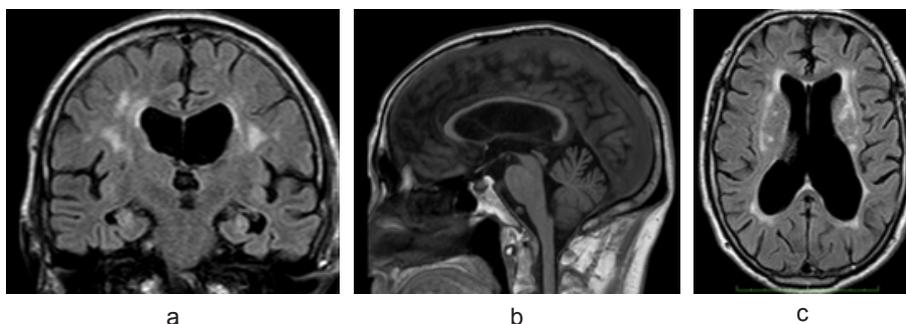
The patient's MRI (description above)
